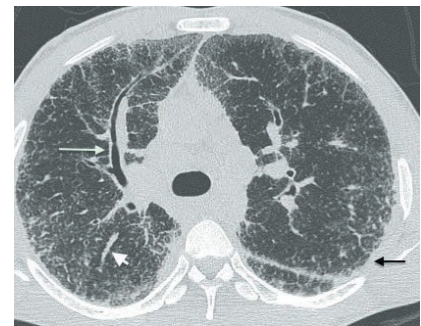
High-resolution CT scan changes of sarcoidosis – bronchial wall thickening (white arrow), beading of bronchovascular bundles (arrow head), and sub-pleural nodularity (black arrow).
